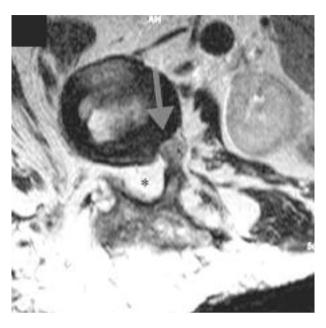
Axial MRI T12/L1 : lipomatosis filling the spinal canal (*); the spinal cord is shifted to the left (arrow).
